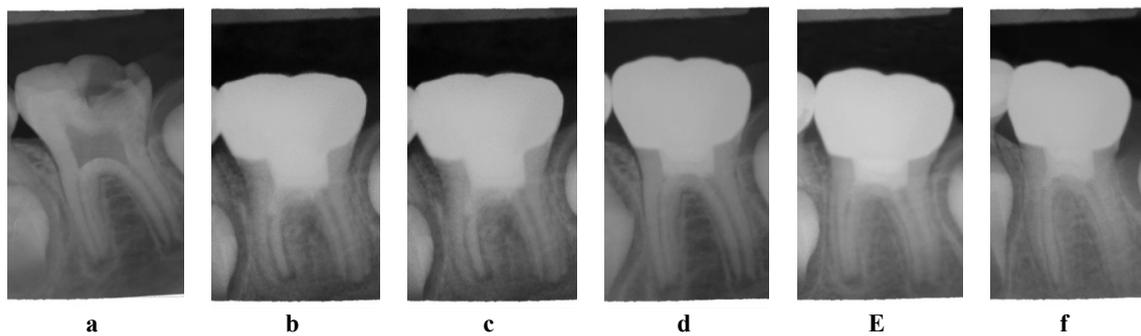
a) Pre-operative periapical radiograph of a mandibular right first molar of a 7-year-old patient, b) immediate post-operative radiograph after apexogenesis with MTA, c) 3 month follow-up radiograph, d) 6 month follow-up radiograph, e) 9 month follow-up radiograph, f) 12 month follow-up
